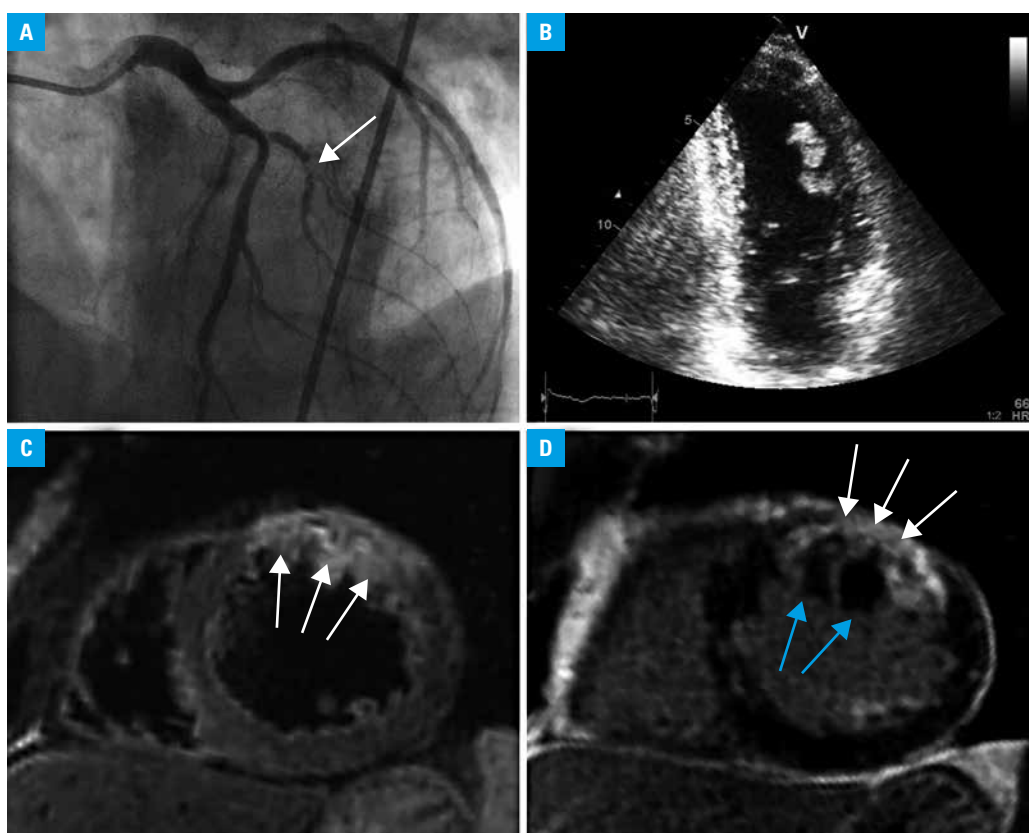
Multimodality imaging in a 48-year-old man with hypereosinophilic syndrome and recurrent non-ST-segment elevation myocardial infarction (NSTEMI). Invasive coronary angiography (A) revealed in-stent thrombosis in the first diagonal branch of the left anterior descending coronary artery (arrow). Transthoracic echocardiography (B) performed 14 days after NSTEMI showed 2 mobile thrombi pedunculated to an akinetic mid anterior segment. Cardiac magnetic resonance confirmed akinesis of the mid anteroseptal and anterior segments and demonstrated myocardial edema (C) in the mid anterior segment (arrows) using the STIR sequence. Postcontrast magnetic resonance imaging (D) revealed: a) transmural late gadolinium enhancement (LGE) in the mid anterior and anteroseptal segments (white arrows) representing myocardial infarction, and b) linear intramural LGE in the mid septal segment, subendocardial LGE in the mid septal and mid lateral segments, and subepicardial LGE in the mid lateral segment, representing nonischemic injury. Two mobile thrombi pedunculated to an akinetic mid anterior segment (blue arrows) were depicted.
